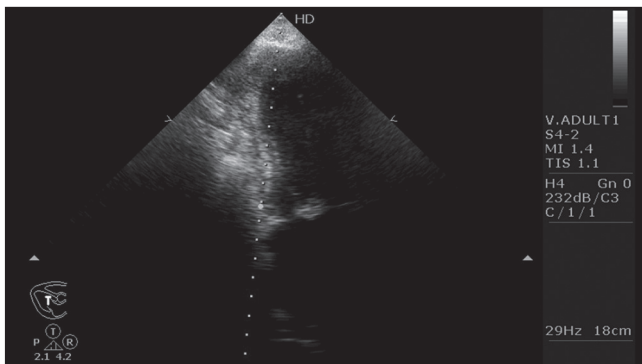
Transthoracic echocardiography showing large vegetation attached to anterior mitral leaflet
